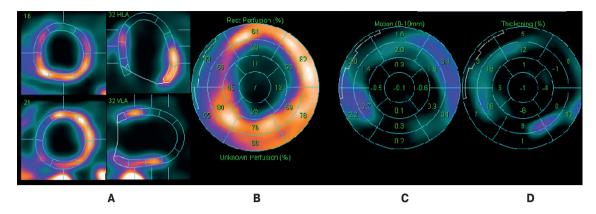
Initial myocardial perfusion SPECT in the patient with ischemic HF. A. Perfusion scintigrams. B. Polar map of LV perfusion. Uneven RP distribution. A large-focal perfusion defect (transmural old myocardial infarction) of the apex, apical and middle segments of the anterior, anterolateral walls with spread to the apical and partially middle segments of the anterior septal wall and apical segments of LV inferior wall with a total area of about 40% of LV is visualized. C. Polar map of systolic LV wall motion. LV dilatation, diffuse hypo(a) kinesis, dyskinesis of the apex, apical segments of the lateral, septal walls of LV (signs of fibromuscular aneurysm, EDV of 411 ml, ESV of 378 ml, stroke volume of 33 ml, LVEF of 8% (N>50%) with heart rate of 84 bpm, cardiac output of 2,7 l/min). D. Polar map of LV systolic wall thickening. Systolic thickening of all LV walls is sharply reduced.
